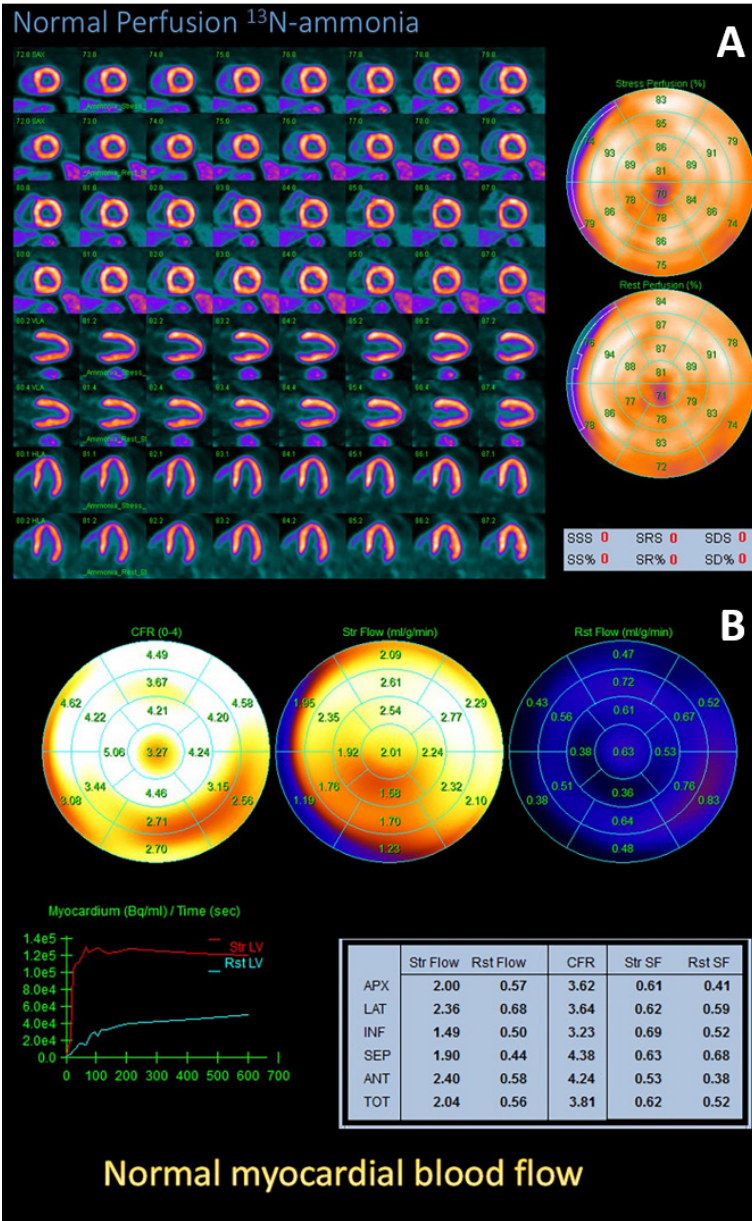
Normal MPI with ^{13}N ammonia PET-CT. (A) The short and long axis of tomographic slides and polar map show no perfusion defect. Semiquantitative scoring system reports score zero for all parameters. (B) Polar maps and time-activity curves of absolute regional MBF in $\text{mL}\cdot\text{g}^{-1}\cdot\text{min}^{-1}$ at stress and rest.
